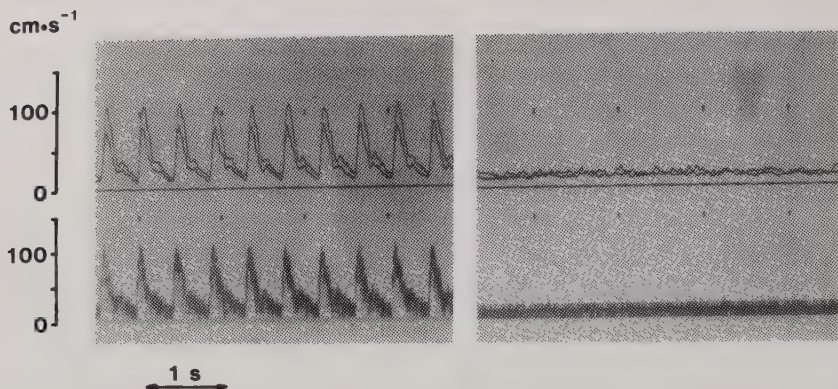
Blood velocity signals recorded from the descending thoracic aorta (left) and umbilical vein (right) of a 34-week-old fetus. Analogue signals of the maximum and mean velocities (upper part) were estimated on-line from the Doppler shift spectrum (lower part). Calibration was corrected for the insonation angle of 45° .
